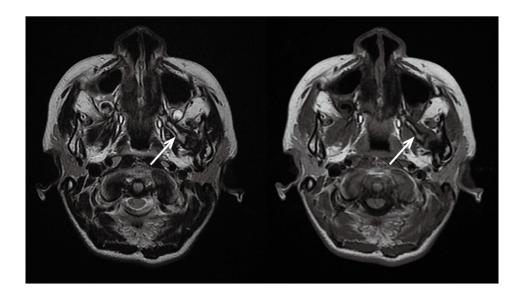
Magnetic resonance images display a hyperintense lesion with T1 and T2 signals, encircled by a hypointense T1 and T2 signal rim in the inferior portion of the left lateral pterygoid (arrow).
